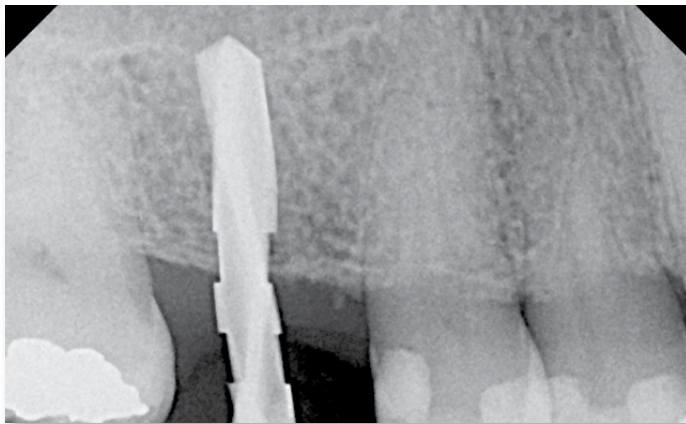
Radiograph of 3.3 mm Twist Drill in site. Note the notches of the drill itself. The first break is at 7 mm, the second at 9 mm. This is intended to be our final depth, just at the floor of the sinus.
